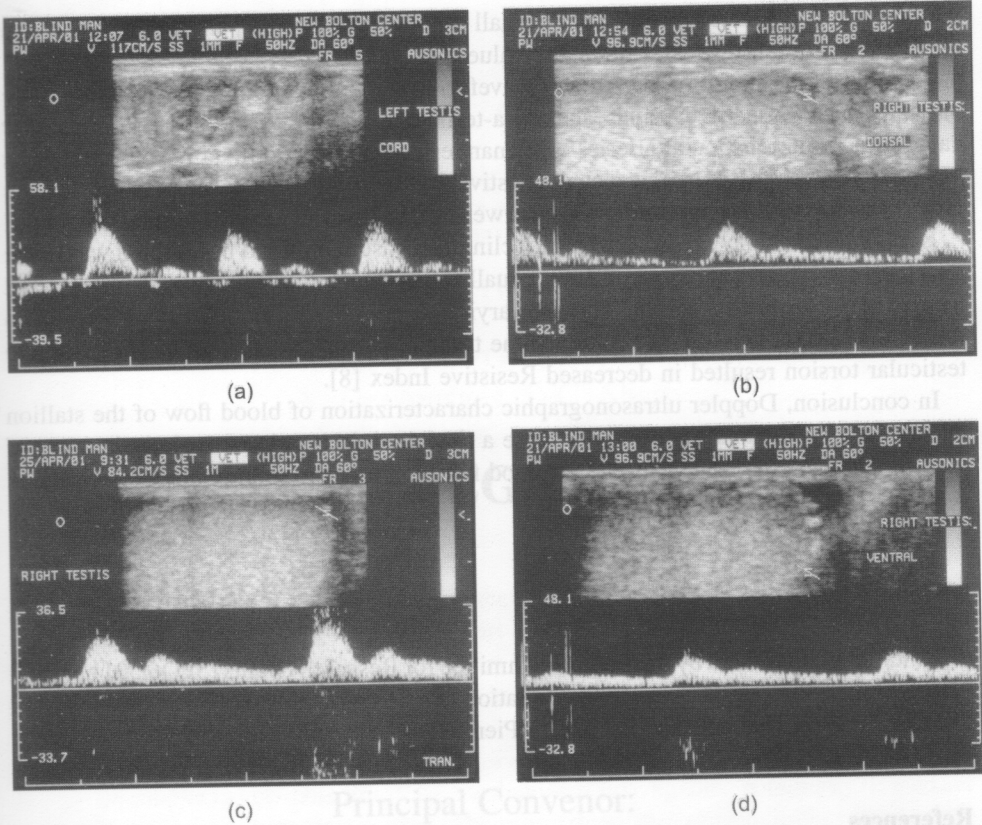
Pulsed Doppler waveforms of a stallion testicular artery at the (a) spermatic cord, (b) proximal location, (c) proximal location with sedation, and (d) distal location.
